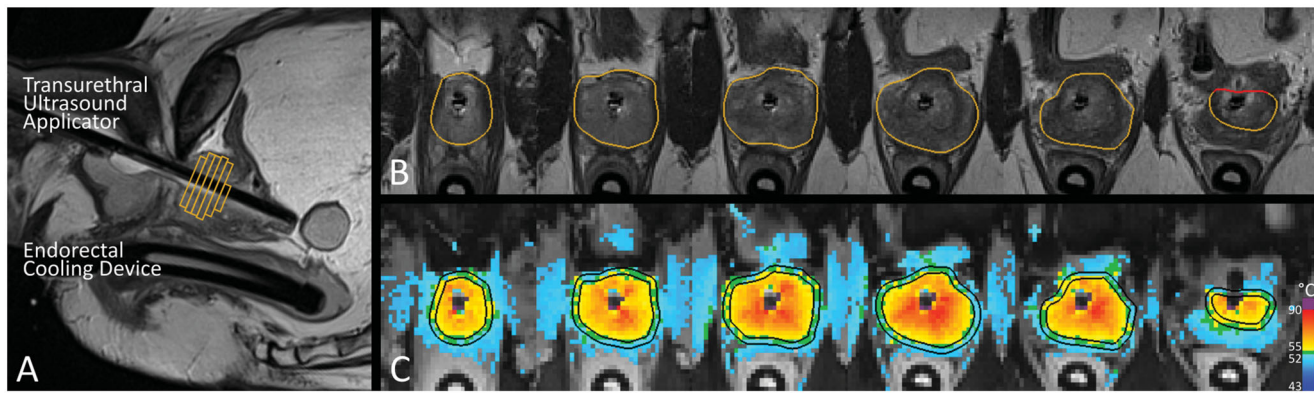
Magnetic resonance imaging-guided transurethral ultrasound ablation of the prostate (TULSA). (A) Sagittal T2-weighted image depicts placement of ultrasound applicator and endorectal cooling device. (B) Overlays indicate locations of target boundaries defined on transverse T2-weighted images from apex (left) to base (right). (C) The physician monitors temperature images acquired dynamically during ablation, which are used by the software to automatically adjust treatment parameters to ensure that thermal necrosis reaches the planned target boundary. In this Phase-I study, ablation extent was limited to a safety margin (inner black contour) set 3 mm inside the prostate capsule (outer contour).
